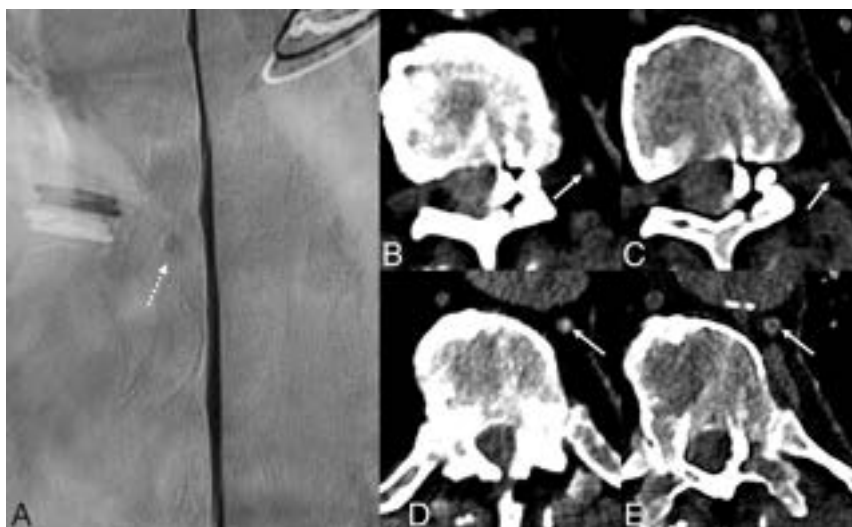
An 80-year-old man with several years of orthostatic headaches but normal brain MR imaging findings (not shown). Representative image from a left lateral decubitus DSM centered at T10 (A) shows a small meningeal diverticulum (A, dashed arrow) but no evidence of a CVF. Axial 40-keV images at 2 adjacent slices from a left lateral decubitus PCD CTM (B and D) demonstrate opacification of a paraspinal vein (B, arrow) and the azygous and hemiazygous vein (D, arrow), consistent with a CVF. Axial 40-keV images at the same slices obtained 30 seconds later (C and E) no longer show contrast within these veins (C and E, arrows). The patient underwent transvenous Onyx embolization of the left T10 CVF.
